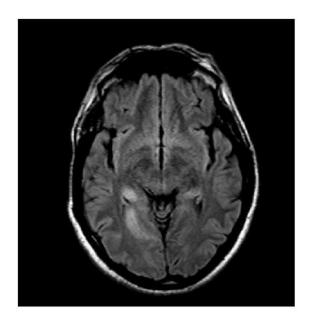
Magnetic Resonance Images: Dreaming patient (#4)
